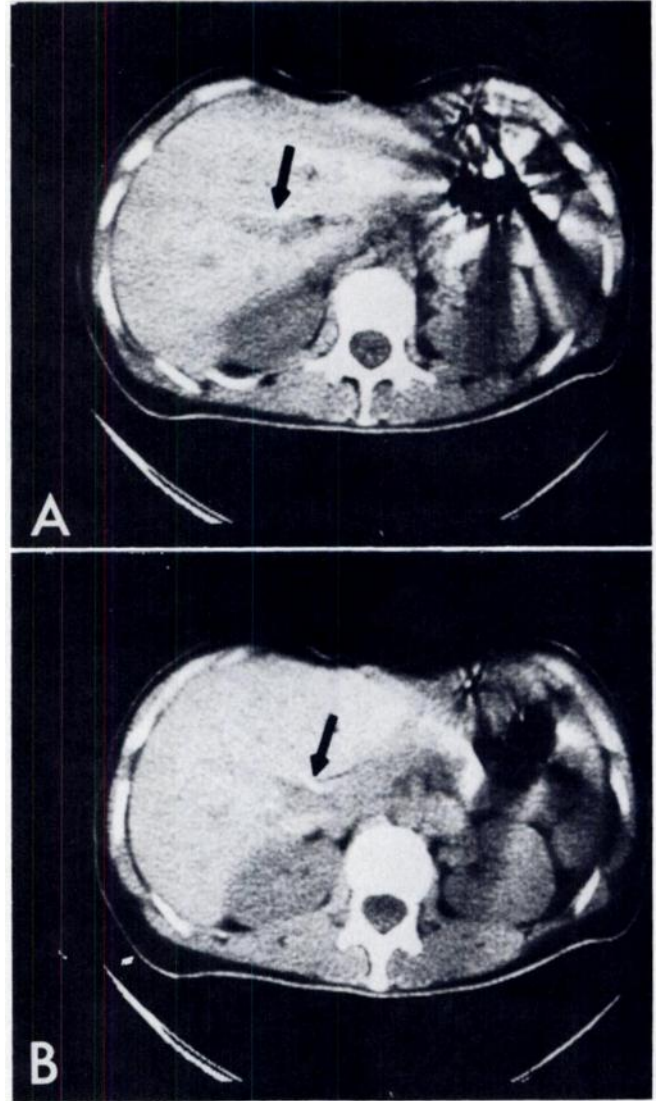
CT scans after administration of cholangiographic material showing that opacified bile ducts (*arrows*) are only very small part of radiolucent portal tracts. Artifacts caused by motion of gas in stomach.
